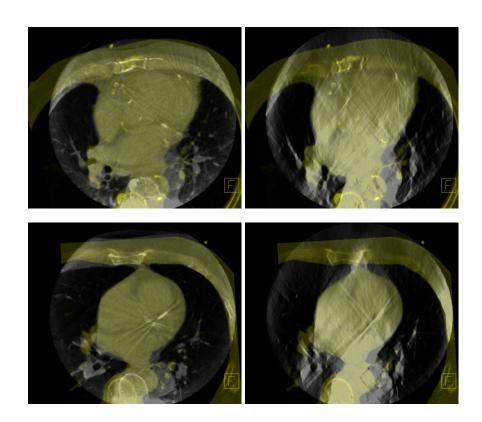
Comparison of fusion of CT with C-arm CT (left), and CT with limited-angle Tomosynthesis images (right). The CT volume is depicted in yellow, the Carm or Tomosynthesis image is depicted in grayscale.
